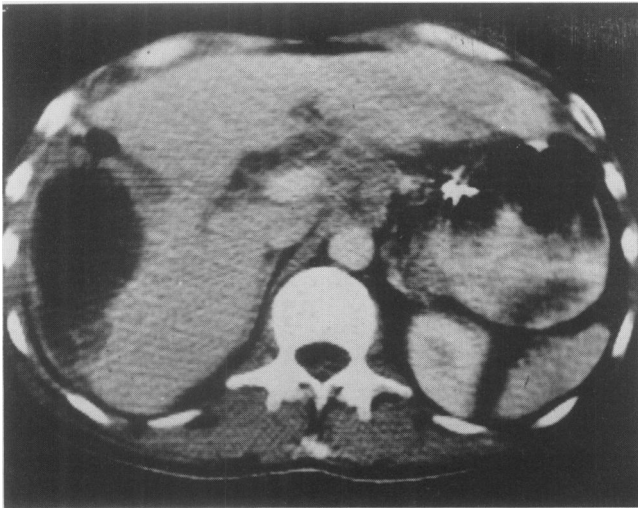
CT demonstrating hepatic abscess after a Whipple procedure.
